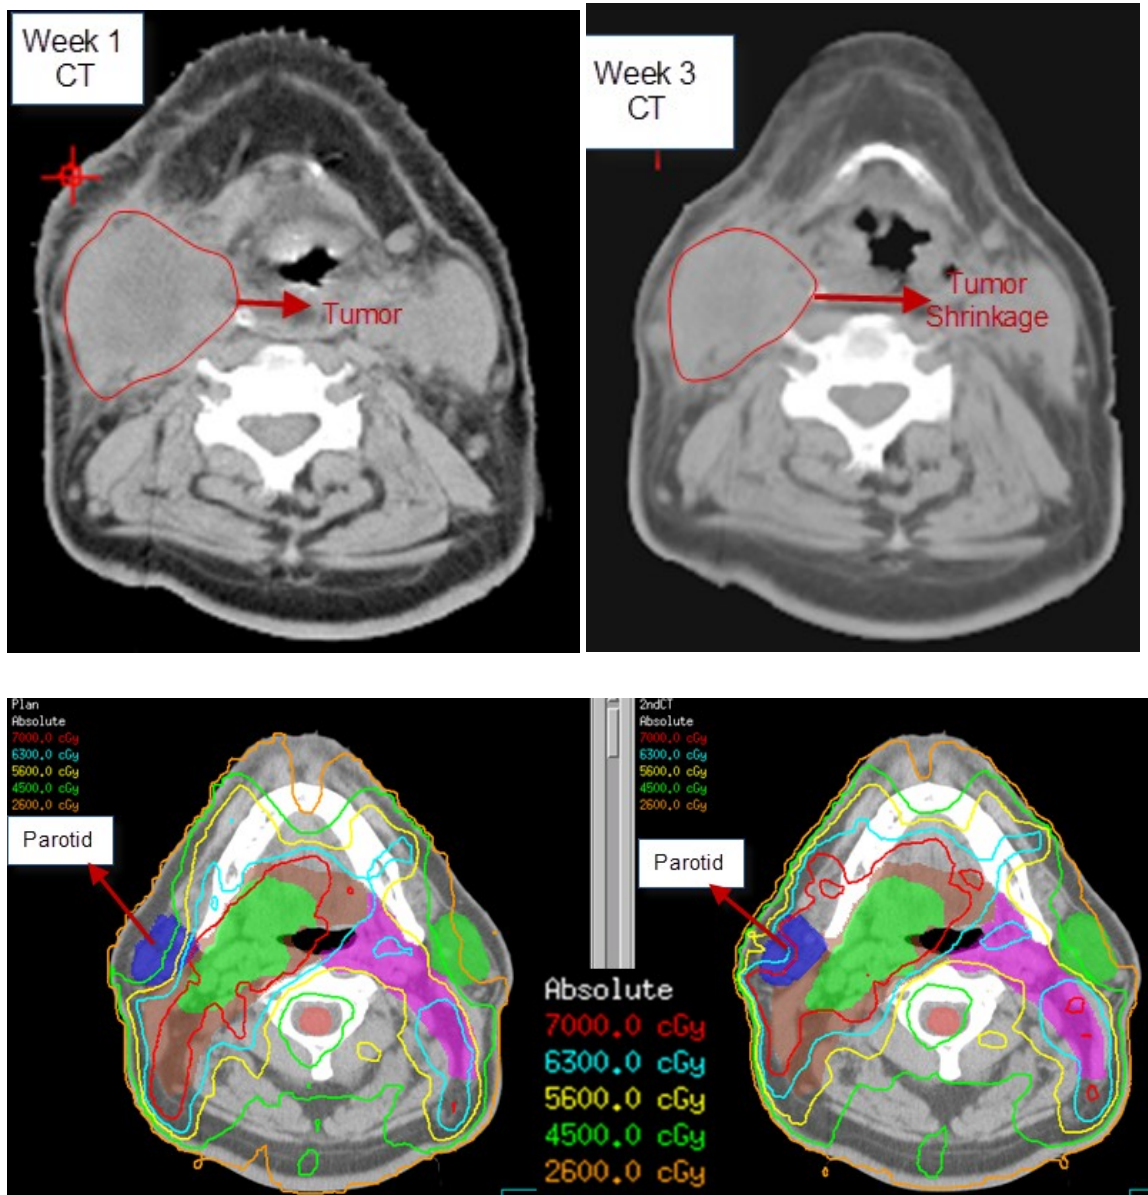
a, Tumor volume at the treatment planning CT scan, b, Tumor volume, 3 weeks after start of treatment showing shrinkage of tumor, c) Isodose distribution on original CT , d) isodose distribution on new anatomy if original plan was delivered without adaptation
